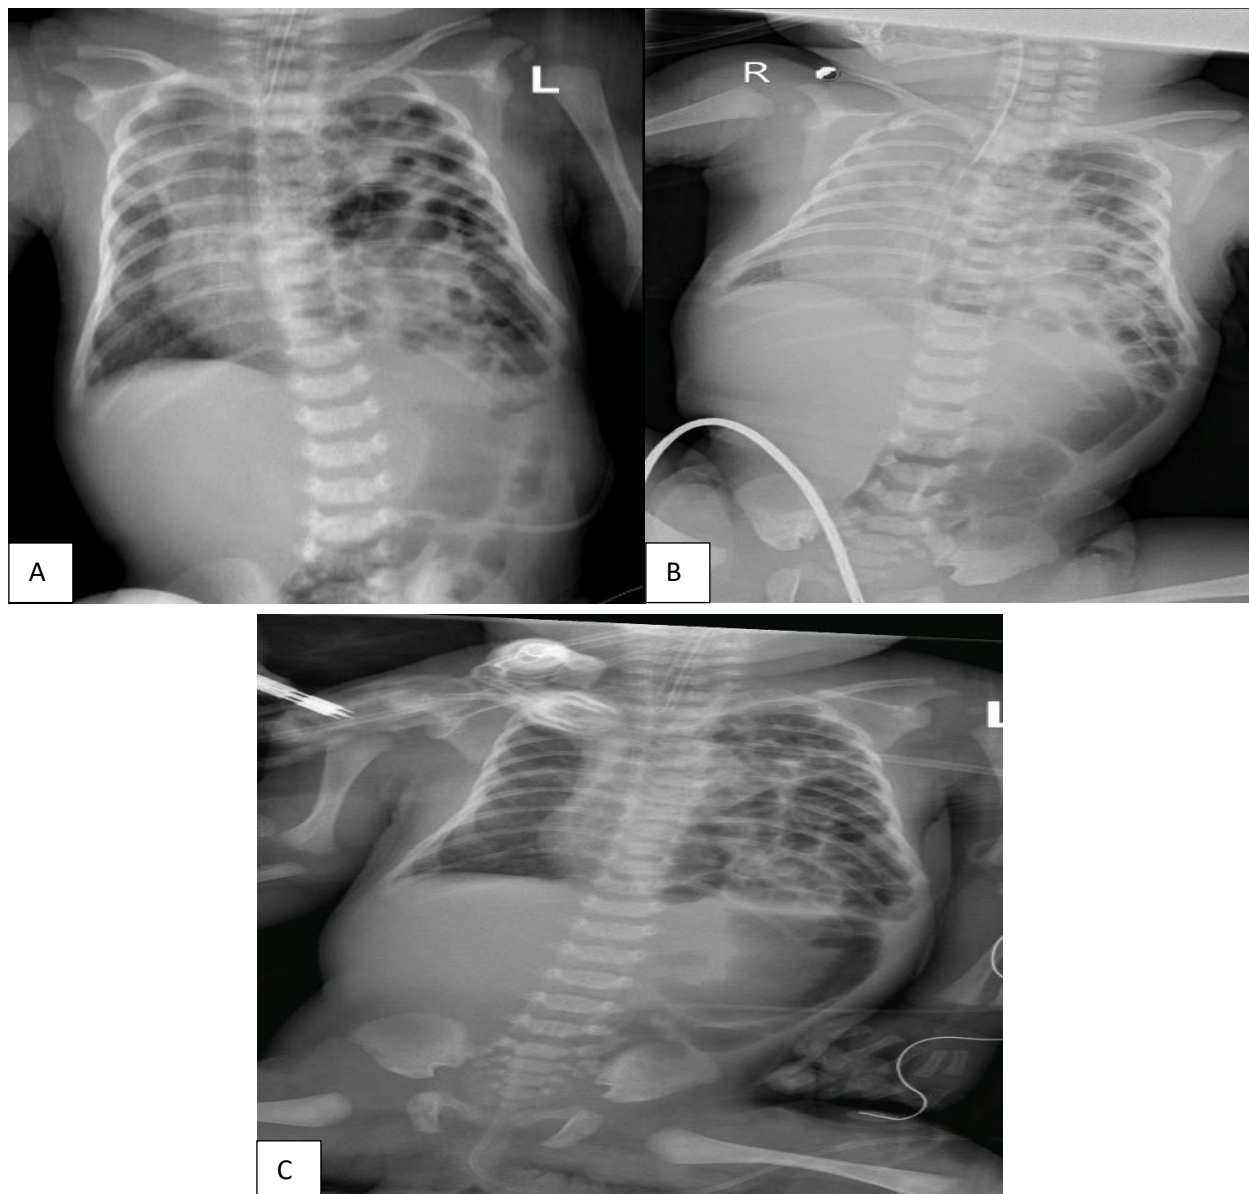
(A-C): Pre-operative x-rays of the patient showing bowel loops in the left side of the thoracic cavity with right sided mediastinal shift. The stomach is seen within the abdominal cavity.
